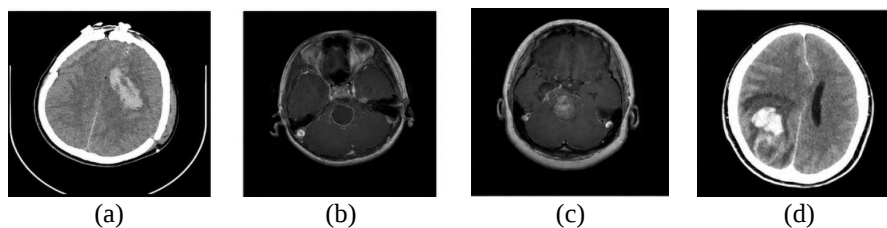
Transformation of modality (CT and MRI); (a) input CT scan, (b) synthesized MRI scan, (c) input MRI scan, and (d) synthesized CT scan
